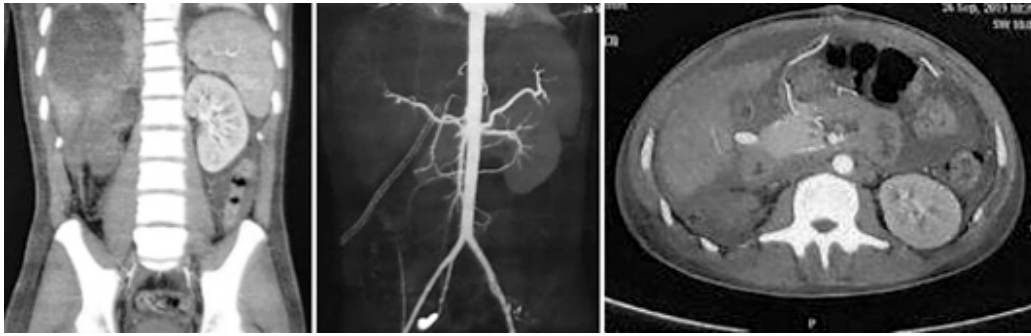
Abdominal CT scan with contrast showed right renal infarct with a 1.7 cm long right renal artery discontinuity from the abdominal aorta.
